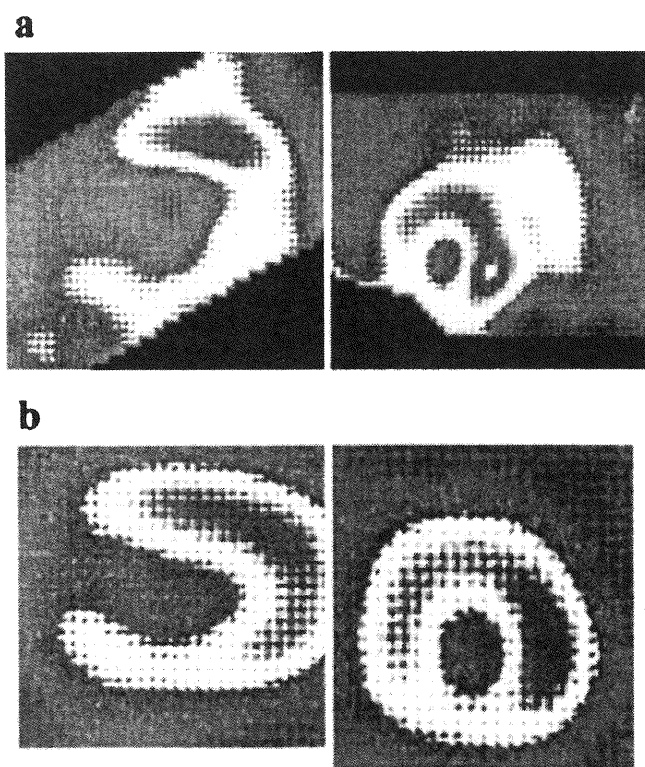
MIBG myocardial SPECT shows persistent low uptake in the infero-posterior area (a); however, [Tc-99m] tetrofosmin SPECT also reveals low uptake in the septum and inferior areas (b), suggesting that reduced MIBG uptake is due to cardiac infarction rather than sympathetic denervation. H/M ratio is 1.84.
